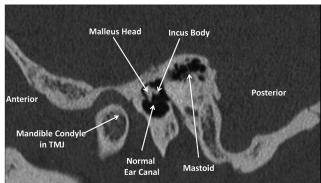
(Left) Sagittal CT image of the right temporal bone showing the separation between the two canals at the level of the annulus showing the ossicles. (Right) Sagittal image of the left temporal bone shows the normal anatomy.
